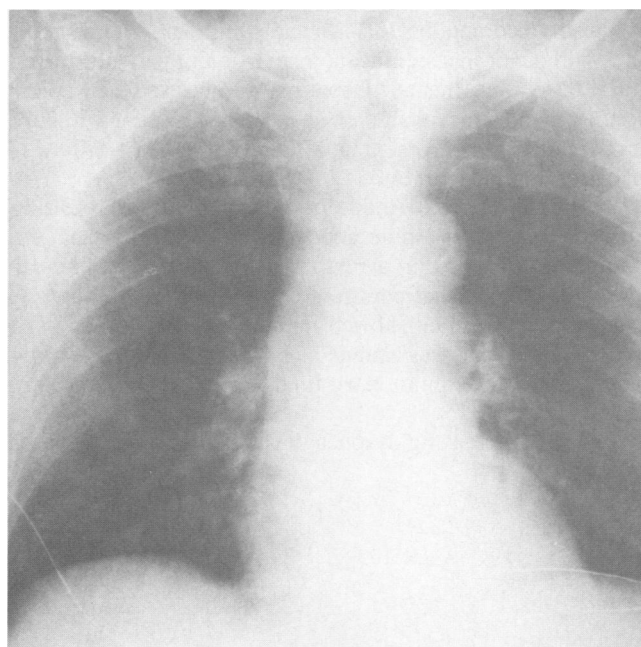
The October 1985 chest x-ray film shows cardiomegaly without evidence of intrinsic pulmonary disease.
